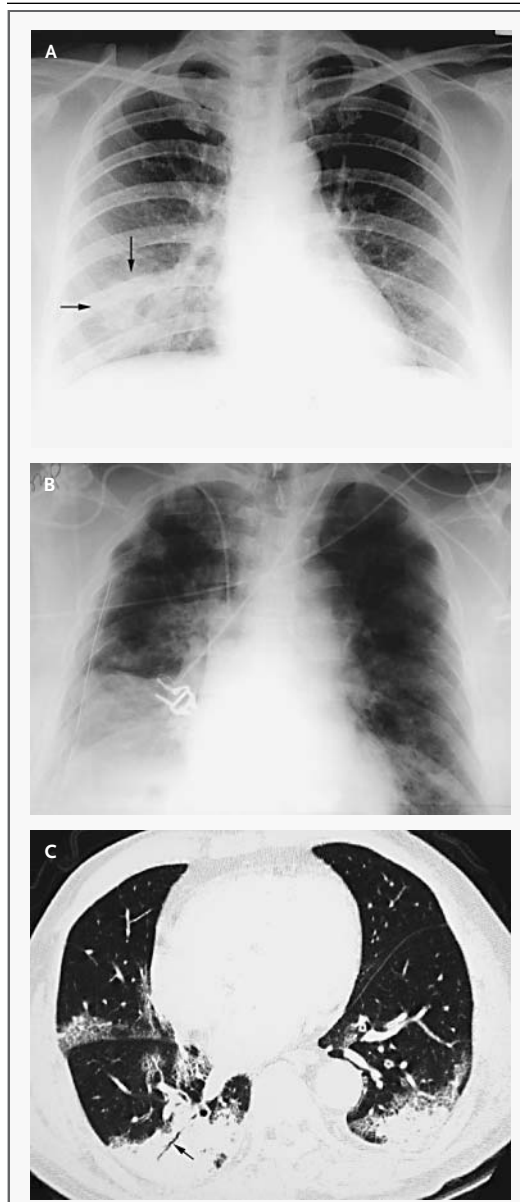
Chest Radiographs of Patient 6 (Panel A), Showing Patchy Consolidation in the Right Lower Zone (Arrows), and Patient 2 (Panel B), Showing Diffuse Involvement of All Lung Zones in Both Lungs, and a High-Resolution CT Scan of Patient 4 (Panel C), Showing Subpleural Areas of Consolidation and Ground-Glass Opacification with Air Bronchogram (Arrow) Affecting the Posterior Aspects of the Lungs, Particularly the Lower Lobes.
